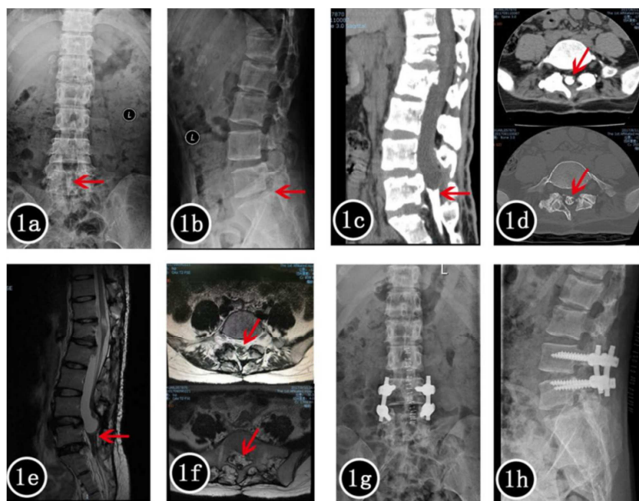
1a and 1b, preoperative lumbar X-ray films showed blurred calcification in lumbosacral spinal canal; 1c and 1d preoperative lumbar CT showed ossification in L5-S1 horizontal spinal canal; 1e and 1f, preoperative lumbar MRI showed abnormal signal in L5-S1 horizontal spinal canal; 1g and 1h, 1 month after surgery, lumbar X-ray films showed that L4/5 vertebral lamina had been removed and internal fixation was well (Red arrows indicate calcified arachnoid membranes).
